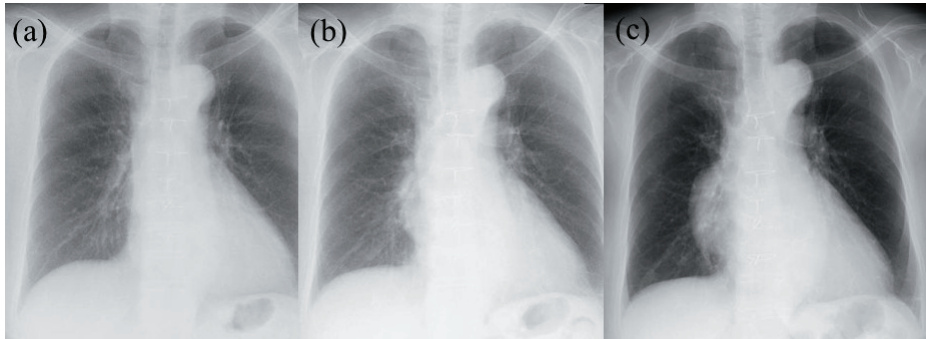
Plain chest x-ray showing mediastinal tumor measuring 2.5 cm in diameter in 2007 (a); 4.5 cm in diameter in 2013 (b); 7.5 cm in diameter in 2016 (c).
